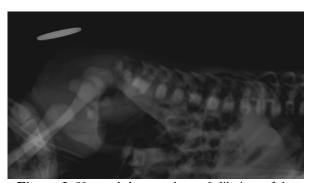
X-ray abdomen showed dilation of the descending and recto sigmoid colon without the gas shadow in the distal rectum and also sacral agenesis
